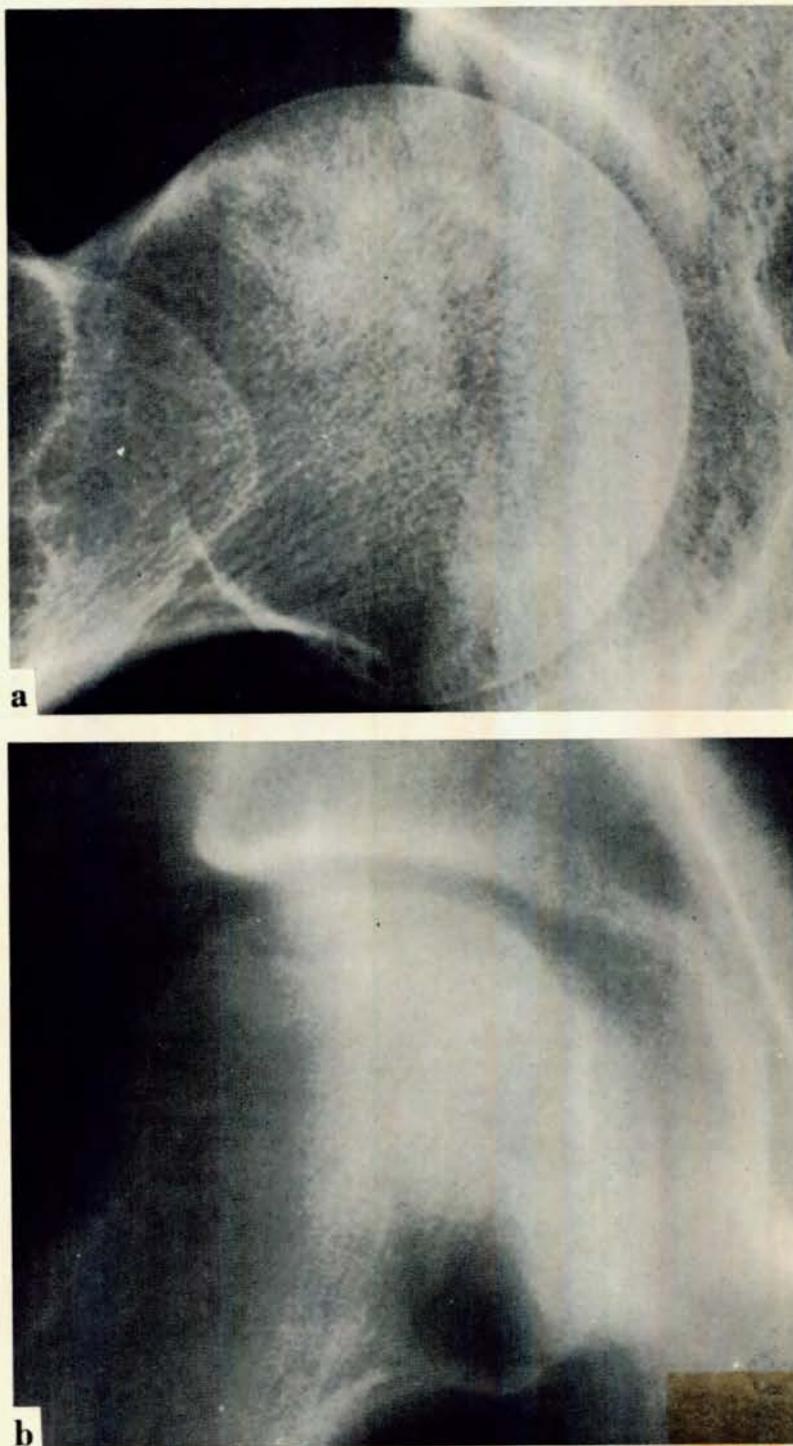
R femoral head of patient who developed Type I decompression sickness near end of 600- and 650-ft dives. (a) Lateral roentgenogram $3\frac{1}{2}$ yr later shows diffuse area of central rarefaction surrounded by patchy sclerosis involving anterior portion of head and extending from region of obliterated epiphyseal line to subchondral region. (b) These findings were confirmed on A-P tomogram, which reveals obvious subchondral irregular radiolucency and sclerosis without evidence of segmental collapse.
